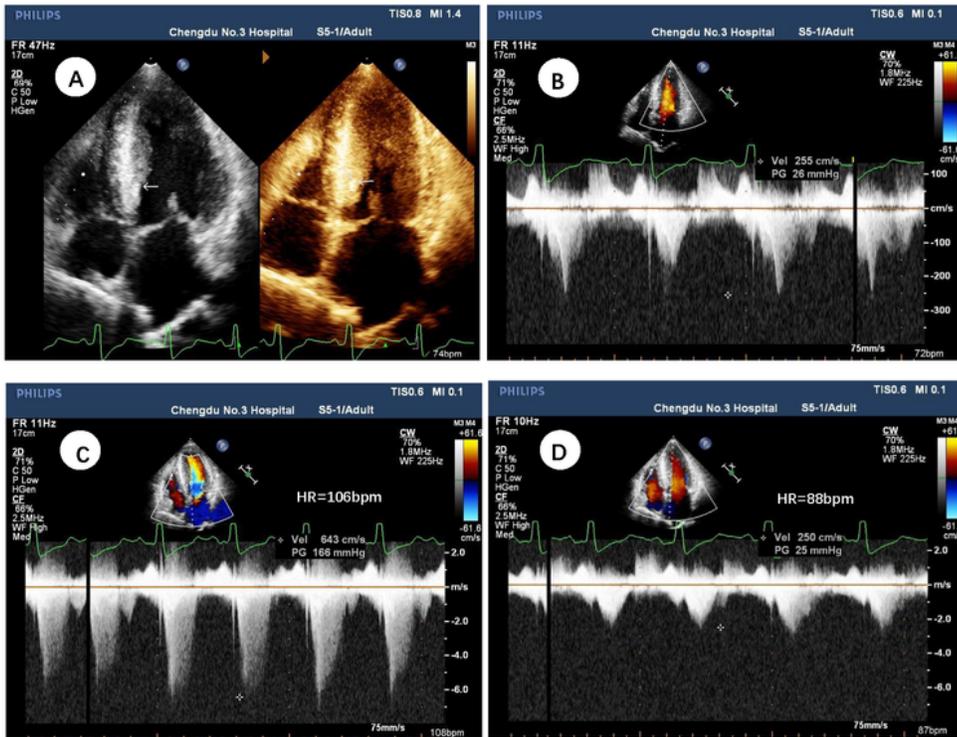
A: four-chamber view with echo-enhanced region notice at the place of ablation. B: Gradients in the left ventricular outflow tract (CW-Doppler) at rest of isoproterenol after ERASH, 26mmHg, HR 78bpm. C: Gradients of LVOT at provocation of isoproterenol after ERASH, 166mmHg, HR 106bpm. D: Gradients of LOVT at provocation of isoproterenol after ERASH, 25mmHg, HR 88bpm.
